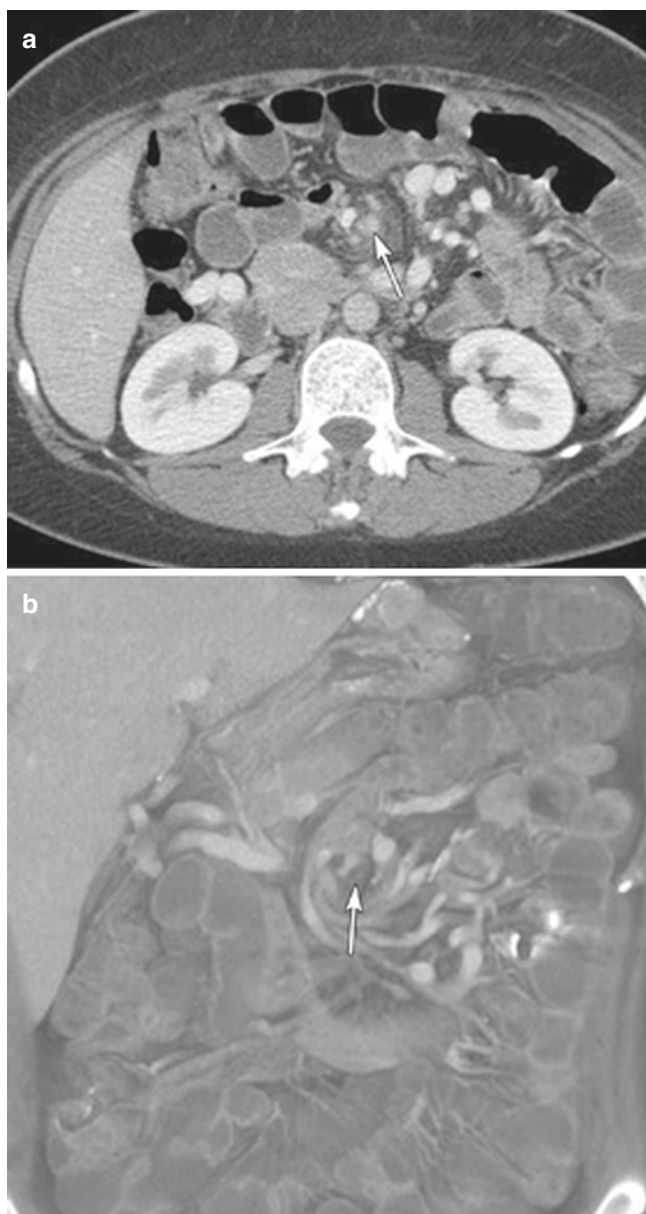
The swirl or whirl sign on CT is seen approximately 80% of the time in patients with a Petersen hernia. (a) Coronal view, (b) transverse view. (From Gaetke-Udager et al. [15])
